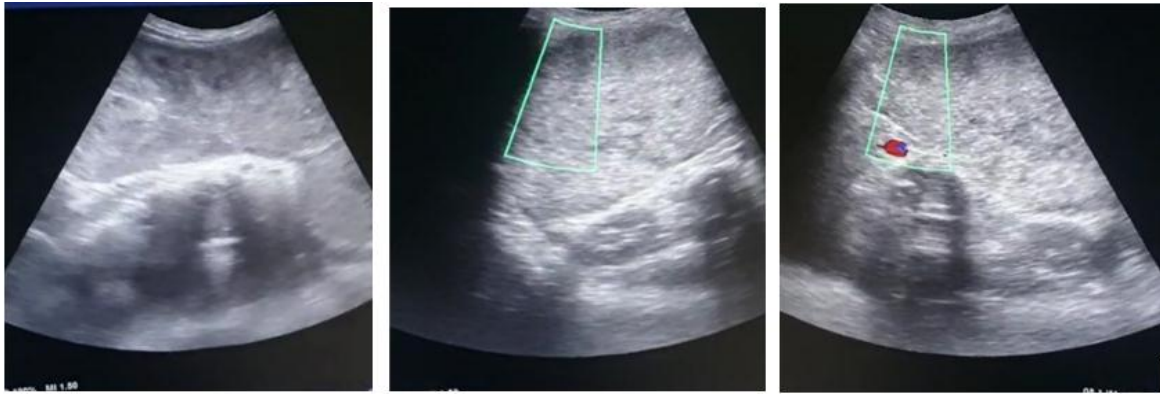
A heterogeneously hyperechoic mass was seen extending from pelvis to right mid abdomen showing no color flow on doppler.
